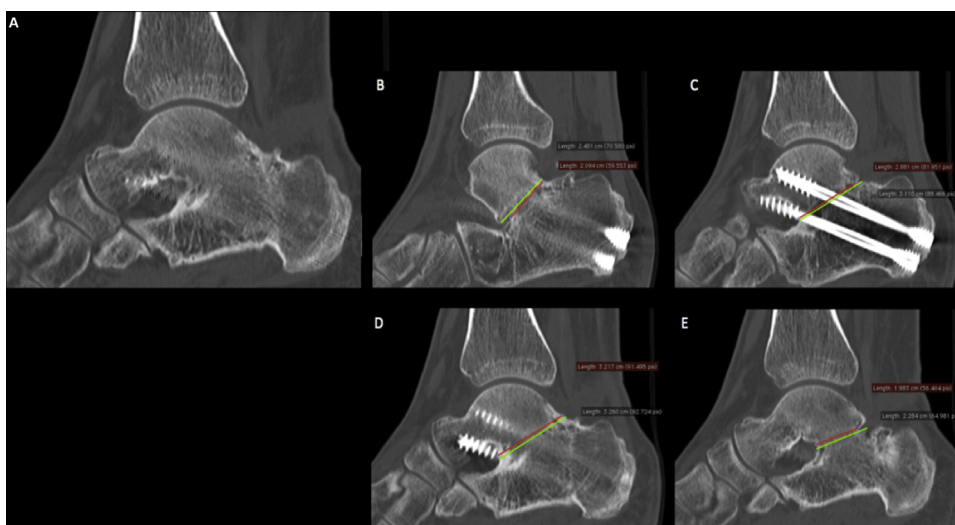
Computed tomodensitometry (CT) fusion ratio in subtalar arthrodesis, following Dorsey. A: CT result of arthroscopic subtalar fusion; B–E: example of fusion ratio measurement for each slice.
